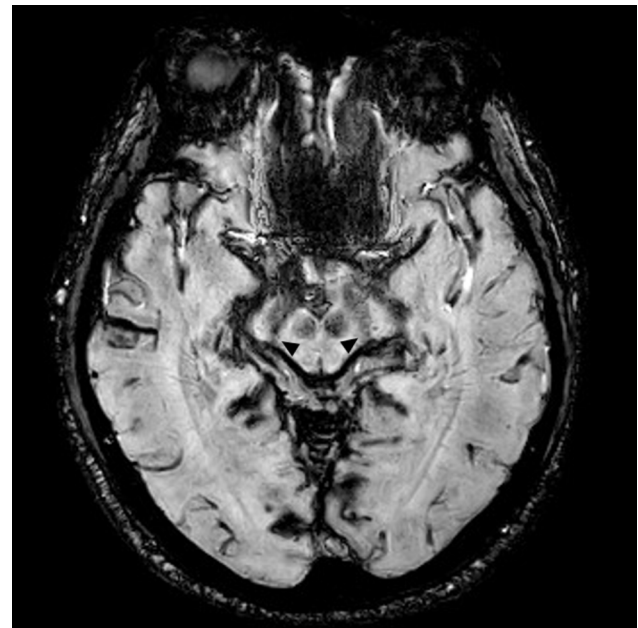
MRI image of August 2021. SWI image showing bilateral absence of the hyperintense signal of nigrosome 1 (black arrowheads). MRI magnetic resonance imaging. SWI, susceptibility-weighted imaging
